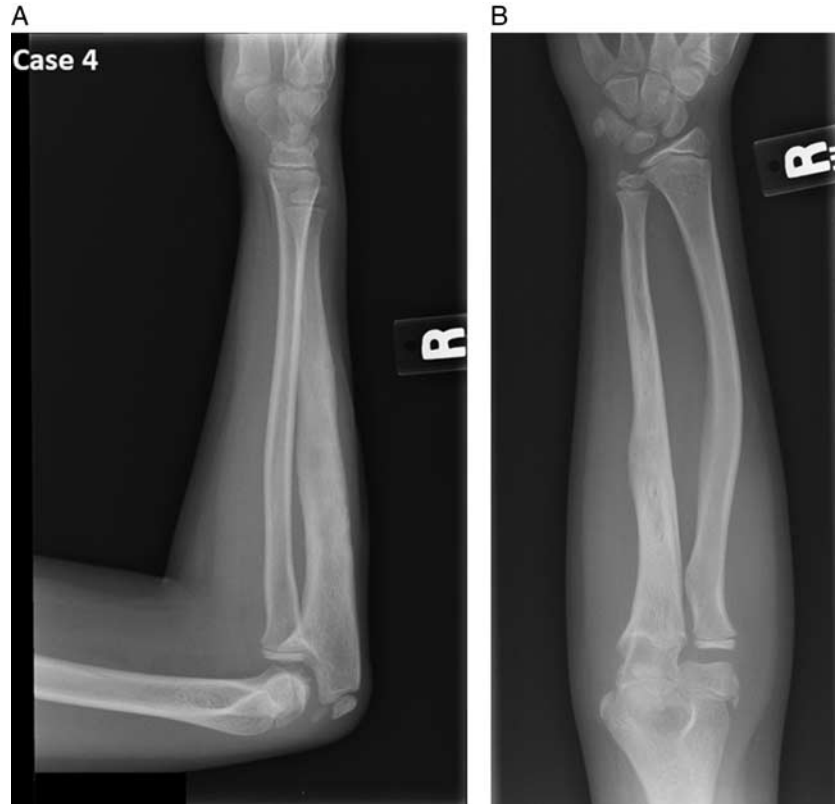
A and B, Case 4: radiographs of the right forearm in a 4-year-old female with bowing and evidence of the focal fibrocartilagenous dysplasia lesion in the distal ulna. The radiocapitellar joint is congruent.
